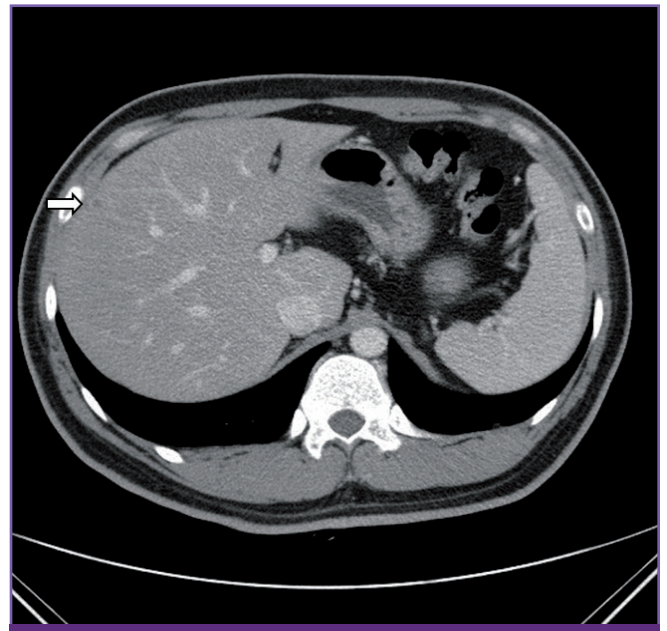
Results of the abdominal computed tomography scan performed on admission indicated a small low-attenuated lesion with enhancing wall (white arrow) in the liver, suggesting a liver abscess. The size of the liver abscess was approximately 8 mm.
